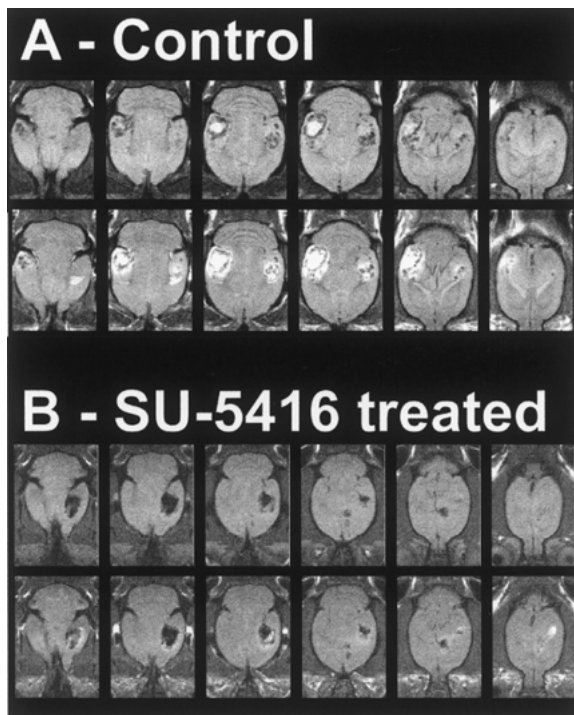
T1-weighted MRI of tumor vasculature and cyst. T1-weighted images were acquired (TR/TE = 750/30) without contrast (upper panels of A & B). 2 ml of 25 mM gadolinium contrast agent (Magnevist) were given via an I.P. catheter and a series of images collected over the next half-hour. Lower panels of A and B were collect 20 min after contrast injection. SU-treated tumor has much lower amounts of contrast enhancement suggesting less vascular permeability.
